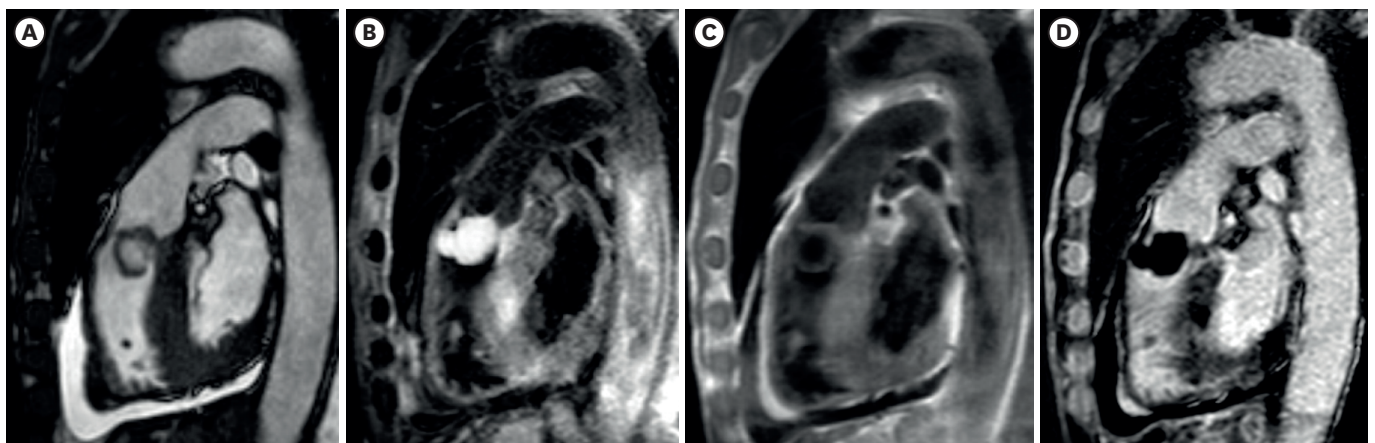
Cardiac magnetic resonance imaging. The mass on the pulmonary valve appeared hollow with hyperintense content in the SSFp sequences (A) and markedly hyperintense (bright) in the triple inversion recovery/T2 sequences (B), hypointense in the double inversion recovery/T1 sequences (C) and markedly hypointense (dark) in the late gadolinium enhancement sequences (D), thus confirming the cystic nature of the mass; besides, in SSFp sequences, the cyst appeared to contain another small cyst structure (daughter cyst). SSFp: steady state free precession.
